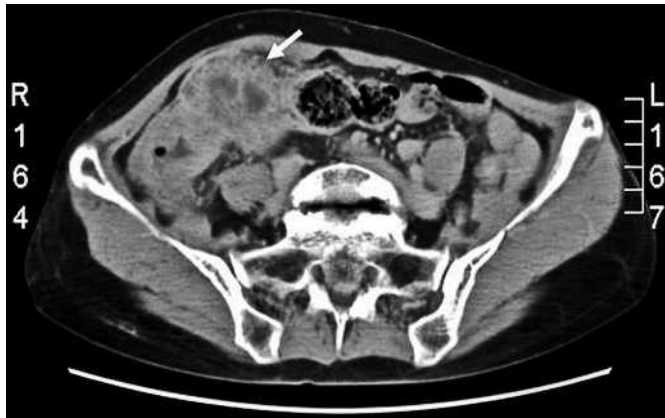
Contrast-enhanced abdominal computed tomography, showing cecal wall thickening and an ill-defined pericecal mass lesion with marginal enhancement (arrow).
